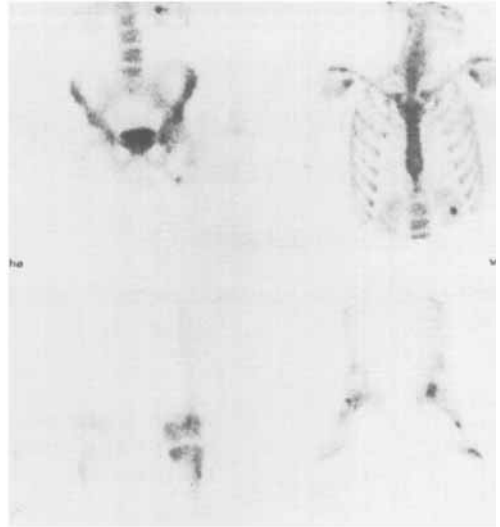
$^{99m}\text{Tc}$ -diphosphate whole body scintigraphy showing high uptake in the left hip joint region, left knee region, left foot and left kidney.
